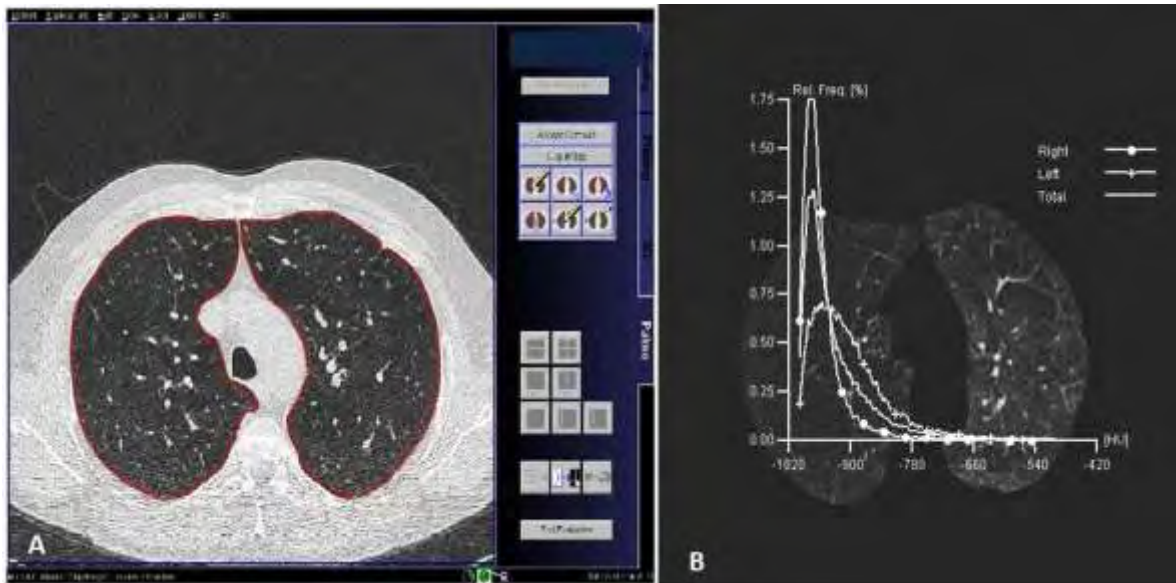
A) Upper slice transferred to the post-processing workstation, where quantitative lung density analysis was performed using the Pulmo CT program. B) Histogram of distribution of lung attenuation values, measured in HU in the upper slice for several potential emphysema thresholds.
